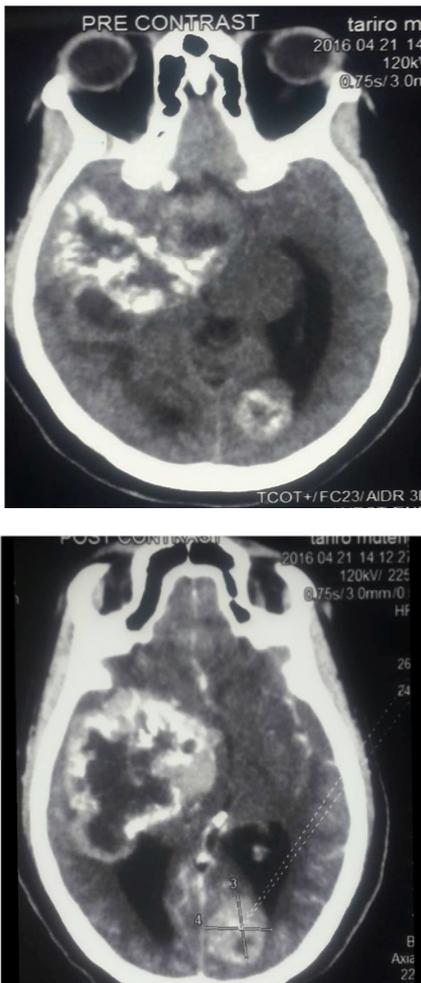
Pre contrast CT scan Brain (left): heterogenous irregular calcified masses, post contrast (Right): extensive leptomeningeal enhanced plus multiple heterogenous lesions compressing the right lateral ventricle with midline shift.
